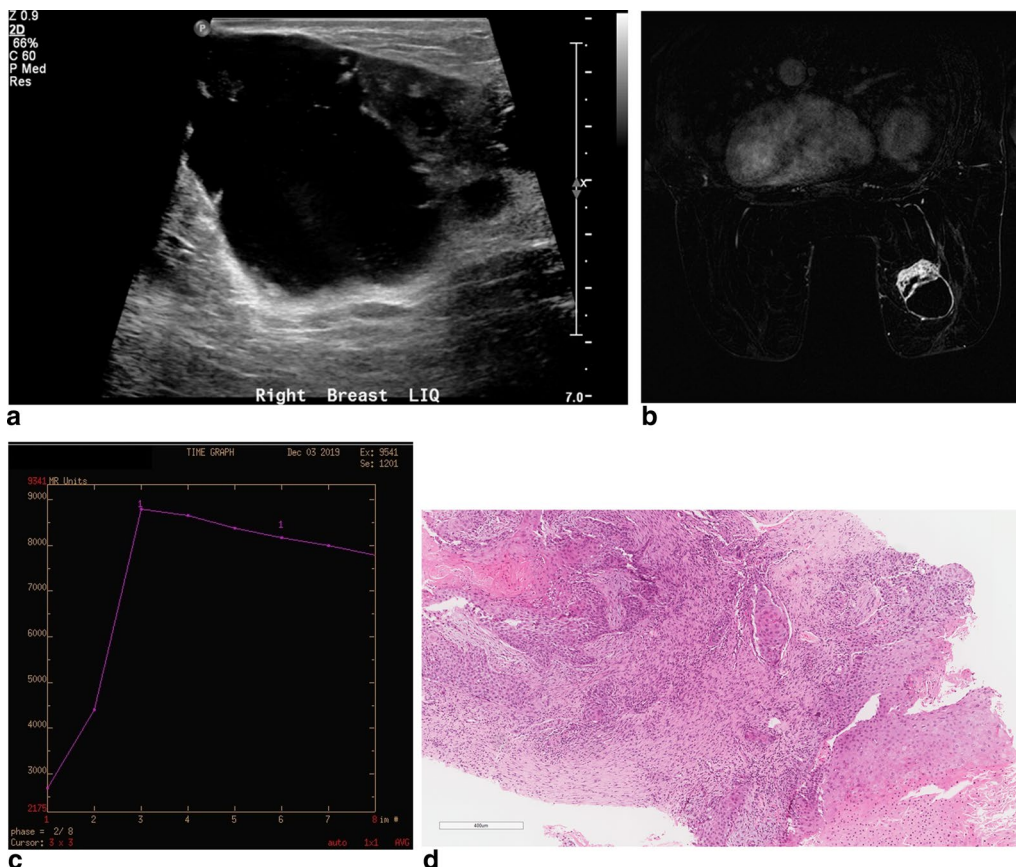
A right breast mass in a 53-year-old woman with squamous cell carcinoma subtype. a The ultrasound shows a complex mass with cystic and solid component at lower inner quadrant. b, c Shows the MRI in dynamic phase that revealed a rim enhanced mass with washout pattern of enhancement. d The pathology slides shows a squamous cell carcinoma
